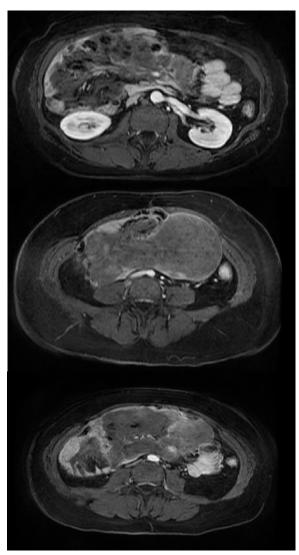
Magnetic resonance imaging scan. Transversal gadolinium enhanced liver acquisition with volume acquision images showing mild enhancement of the lesion with prominent central hypovascularity.
